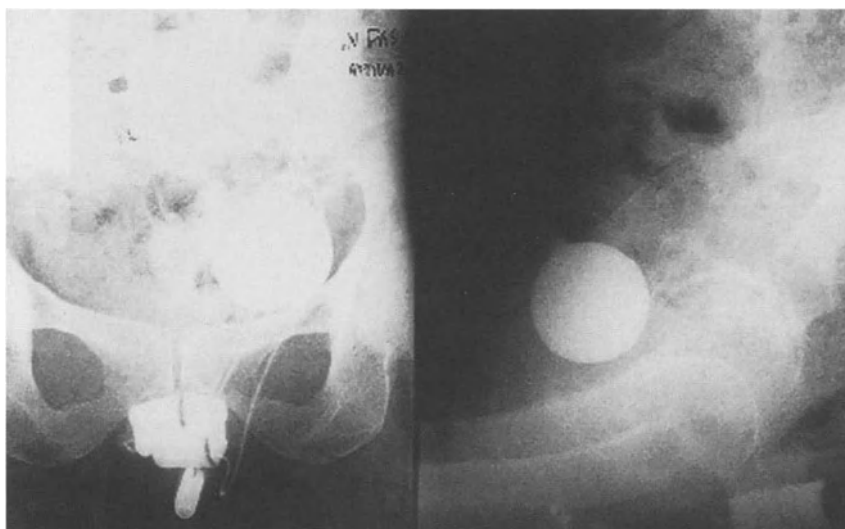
Pelvis X-Ray with the anal cuff inflated
